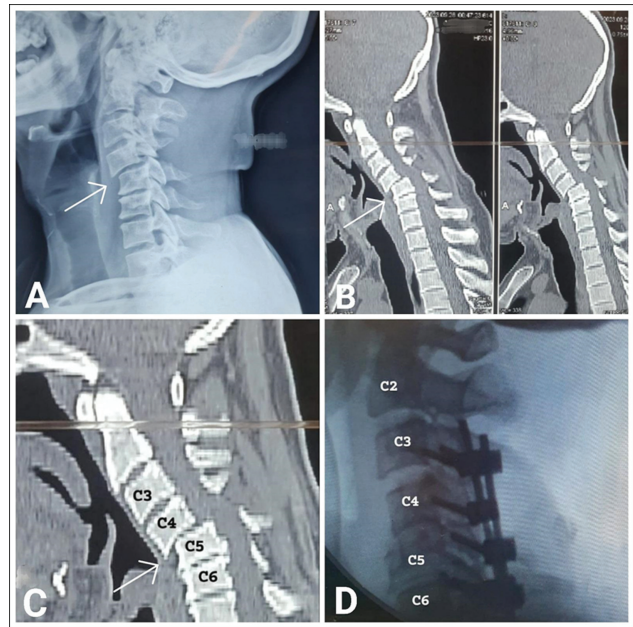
(A) X-ray cervical spine lateral view showing C4 and C5 traumatic subluxation. (B,C) Sagittal cervical spine computed tomography (CT) scan of the same patient. (D) Intraoperative fluoroscopic image showing posterior cervical fixation. (White arrow points C4, C5 subluxation).
